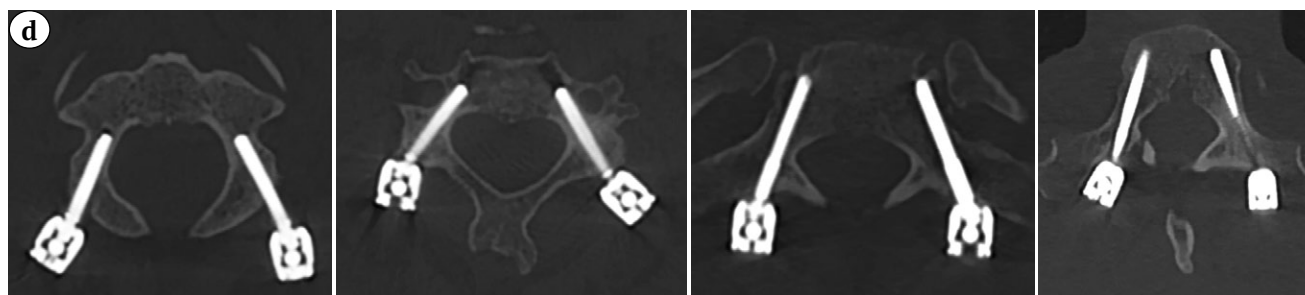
(d). Axial (d) CT: posterior transpedicular screw fixation correct position, solid anterior fusion C3–C7 formation detected
